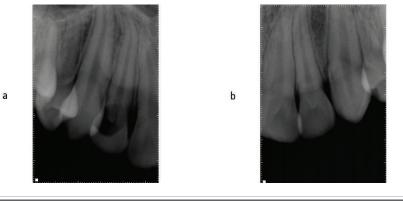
Radiograph revealing an extensive coronal radiolucency typical of the presence of resorption, along with the characteristic signs of dens invaginatus
